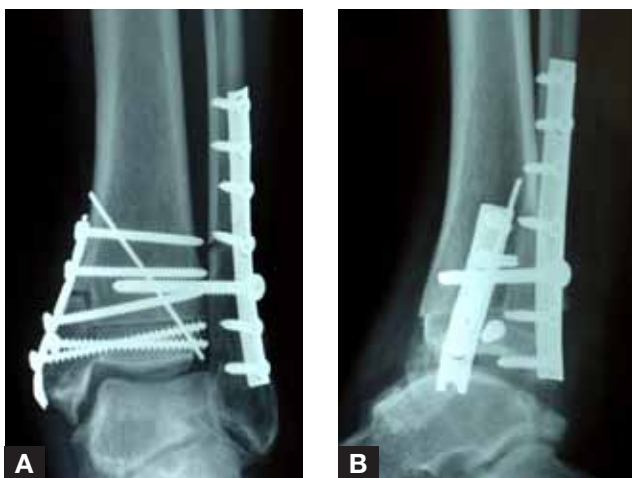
Anteroposterior (A) and lateral (B) radiographs immediately after surgery show excellent anatomical alignment of distal tibial allograft and reconstituted tibiotalar joint space.
